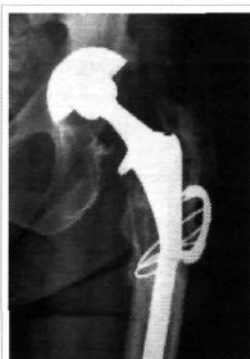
Case 2: Radiograph showing fracture through an Echelon™ stem just distal to the extended trochanteric osteotomy site
